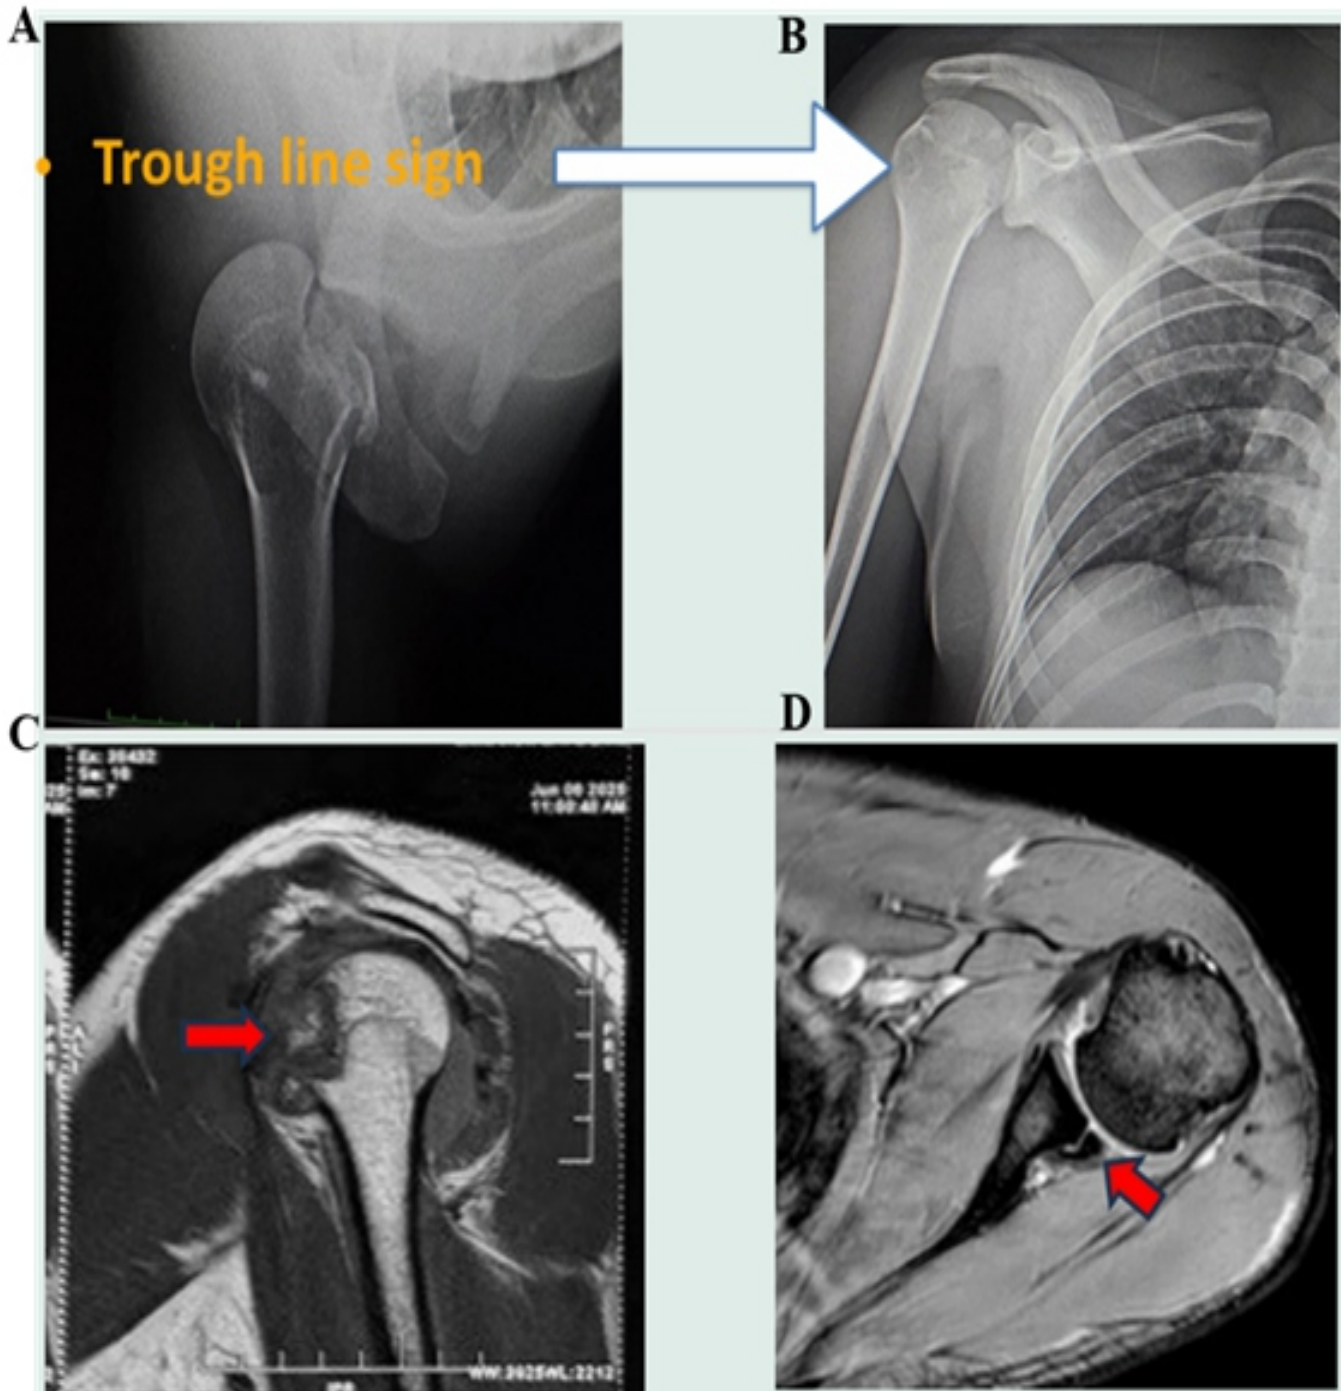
Radiological features of posterior shoulder dislocation with reverse Hill-Sachs lesion. (A) Pre-reduction anteroposterior radiograph of the right shoulder demonstrating the trough line sign (arrow), indicative of an anteromedial humeral head impaction fracture. (B) Post-reduction radiograph showing restoration of glenohumeral alignment. (C) Coronal MRI image revealing a wedge-shaped cortical depression with surrounding marrow edema in the anteromedial humeral head, consistent with a reverse Hill-Sachs lesion (arrow). (D) Axial MRI image demonstrating the reverse Hill-Sachs defect with associated posterior capsulolabral (reverse Bankart) injury (arrow).
